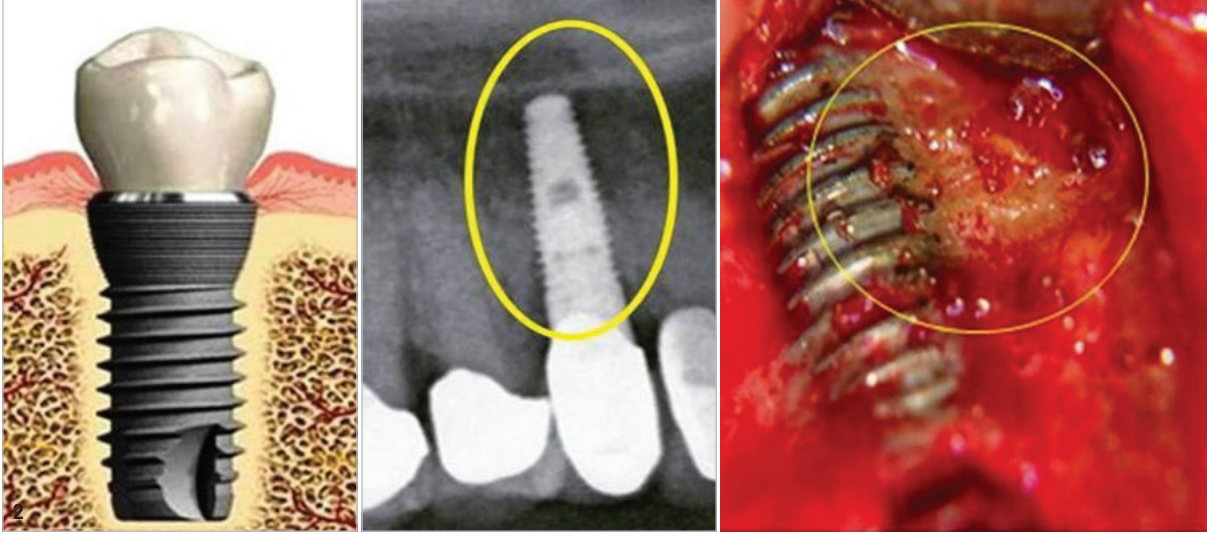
Left: Ideal theory. Centre: Radiography. Right: The actual reduced BIC, converted to FDOJ/BMDJ. Attachment of fatty-degenerative bone (BMDJ) to Ti-Impl (area 13); X-ray does not indicate inflammatory bone loss or significant peri-implantitis.
